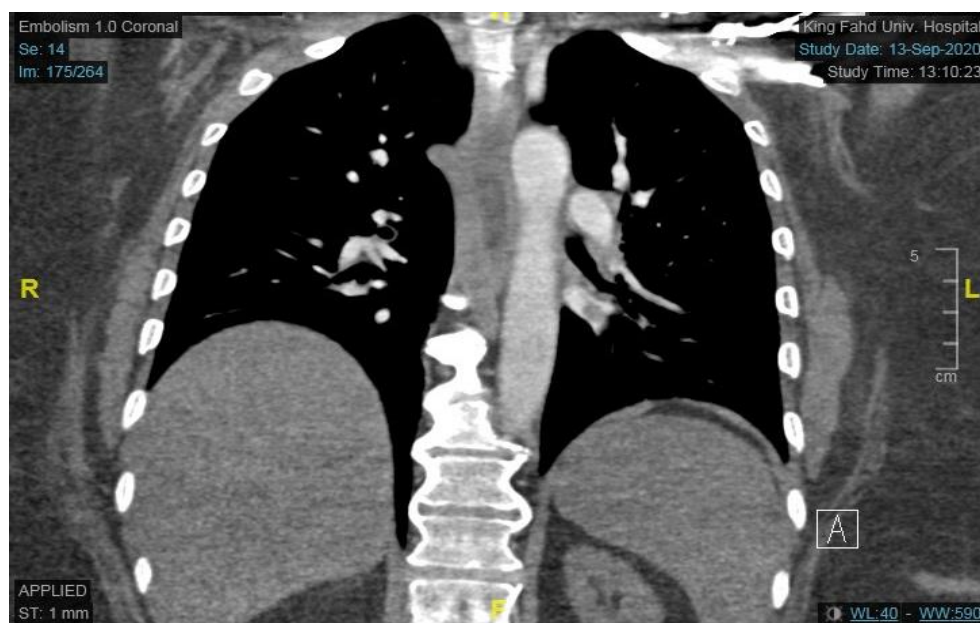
Chest CT angiogram showing left pulmonary vein filling defect.
